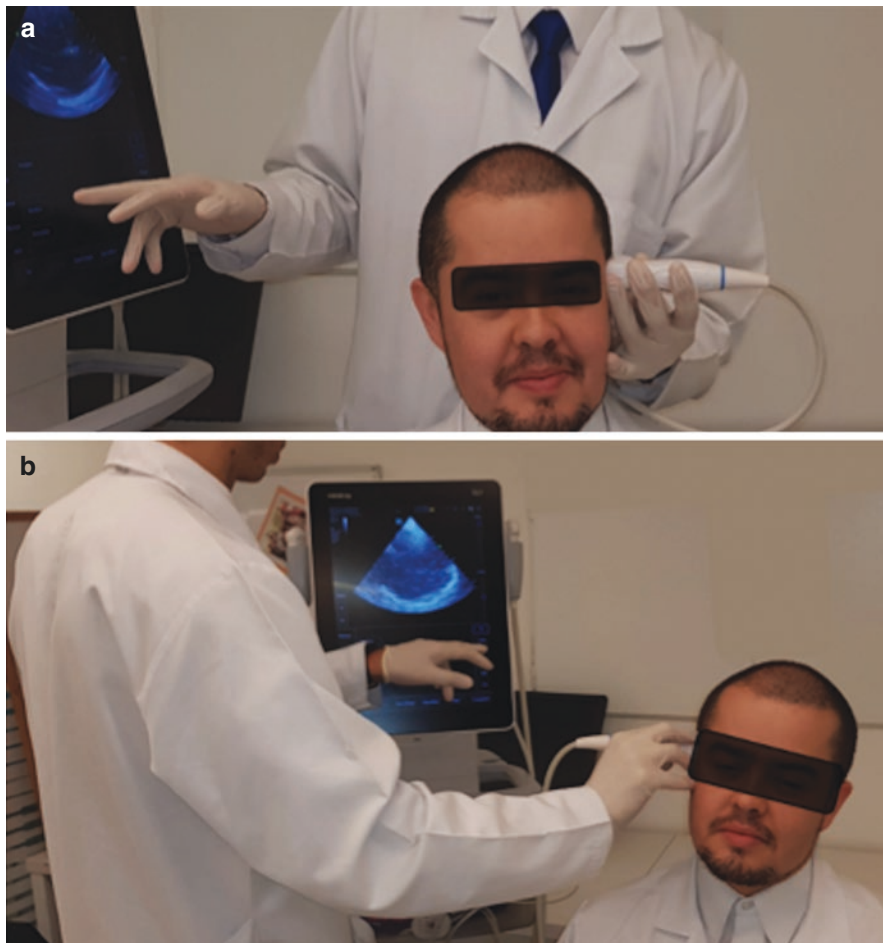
(a) Sonographer/physician position behind the patient, ensuring comfort to perform complete transcranial Doppler evaluation. (Author: Jorge Carrizosa). (b) Physician showing dexterity in transcranial Doppler examination with both hands. (Author: Jorge Carrizosa)
